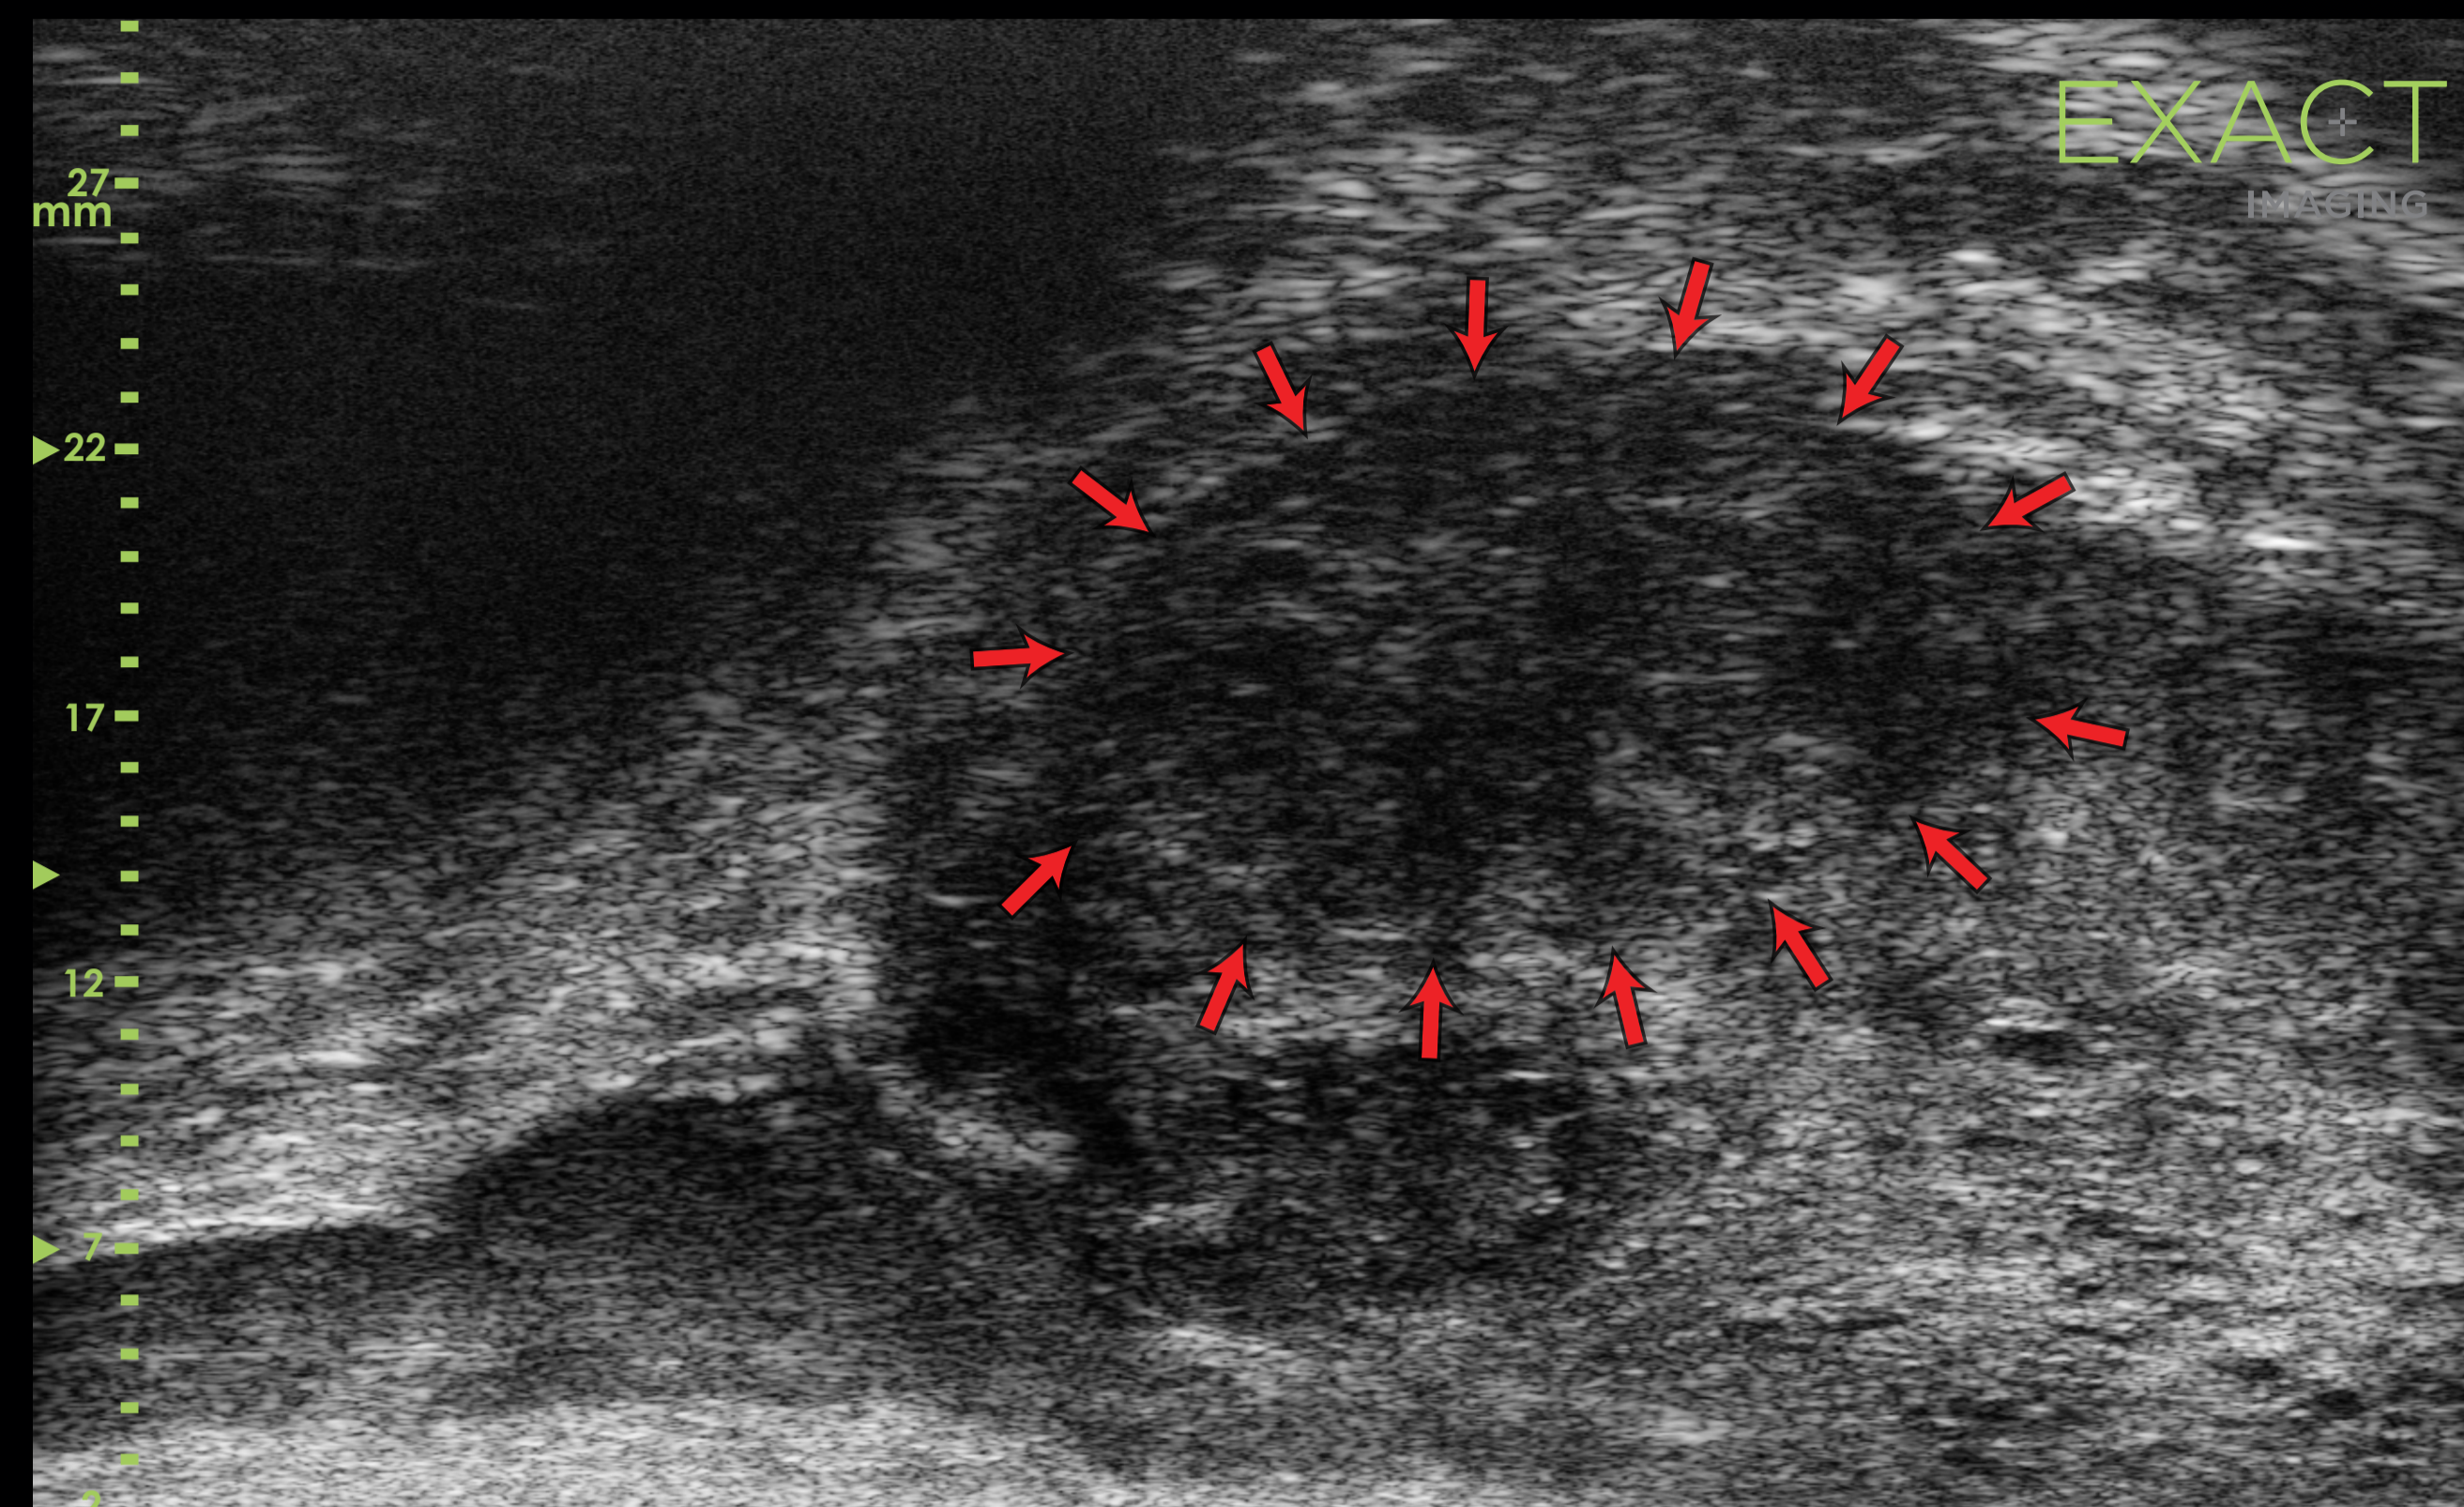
Micro-ultrasound image showing large anterior GG 3 lesion not visualized on mpMRI. In this case mpMRI suggested a target at the contralateral apex only, which was found to contain a lower grade cancer with GG 1.
